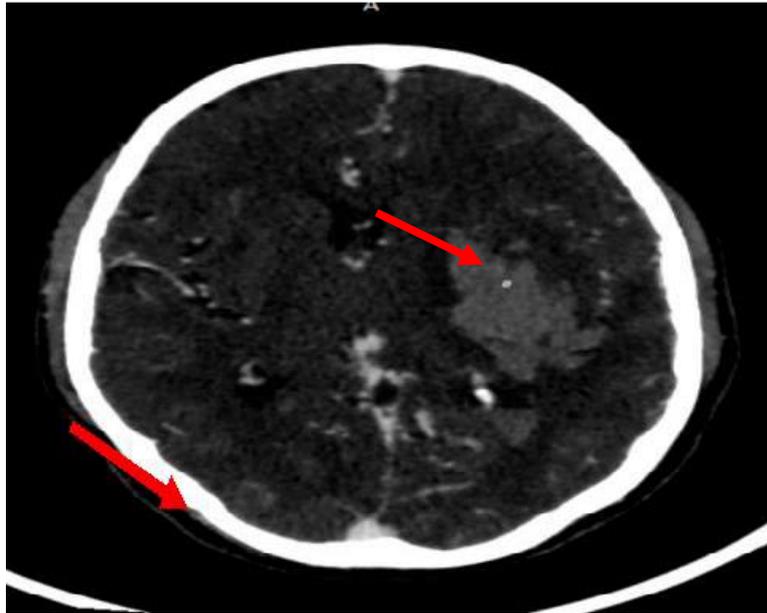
CTA images of a 47-year-old male patient showing a small relatively hyperdense focus (arrow) representing the active contrast extravasation noted within the hematoma (the 'spot sign').
